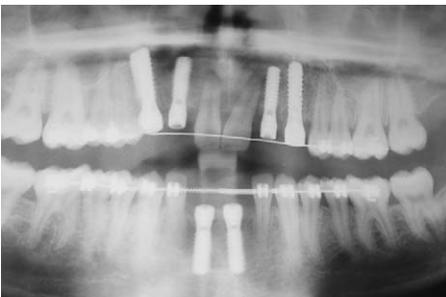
Panoramic radiograph after implant fixture placement.
